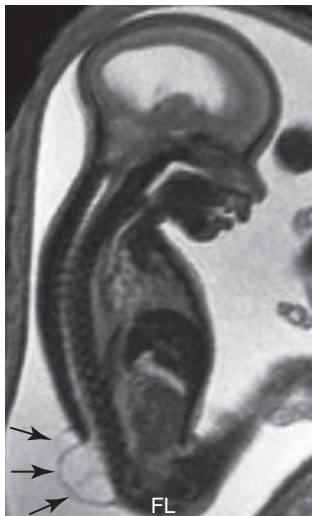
Sagittal T2-weighted fetal magnetic resonance imaging demonstrates a defect within the lumbosacral spine with associated cystic structure consistent with a lumbosacral myelomeningocele. The associated findings of a small posterior image with dilatation of the lateral ventricles, consistent with a Chiari II malformation, are also partially visible.
